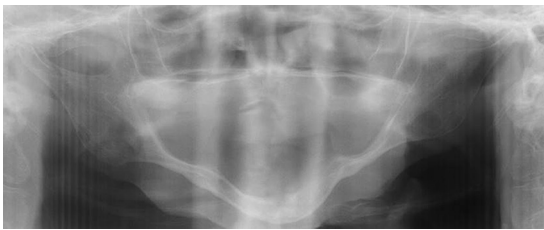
Preoperative panoramic radiographic examination.
